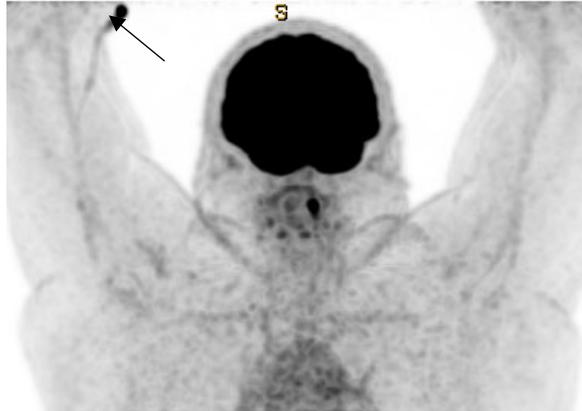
Partial extravasation (arrow) of 18F FDG in a patient in whom the reconstructed study excluded the injection site from the field of view.
